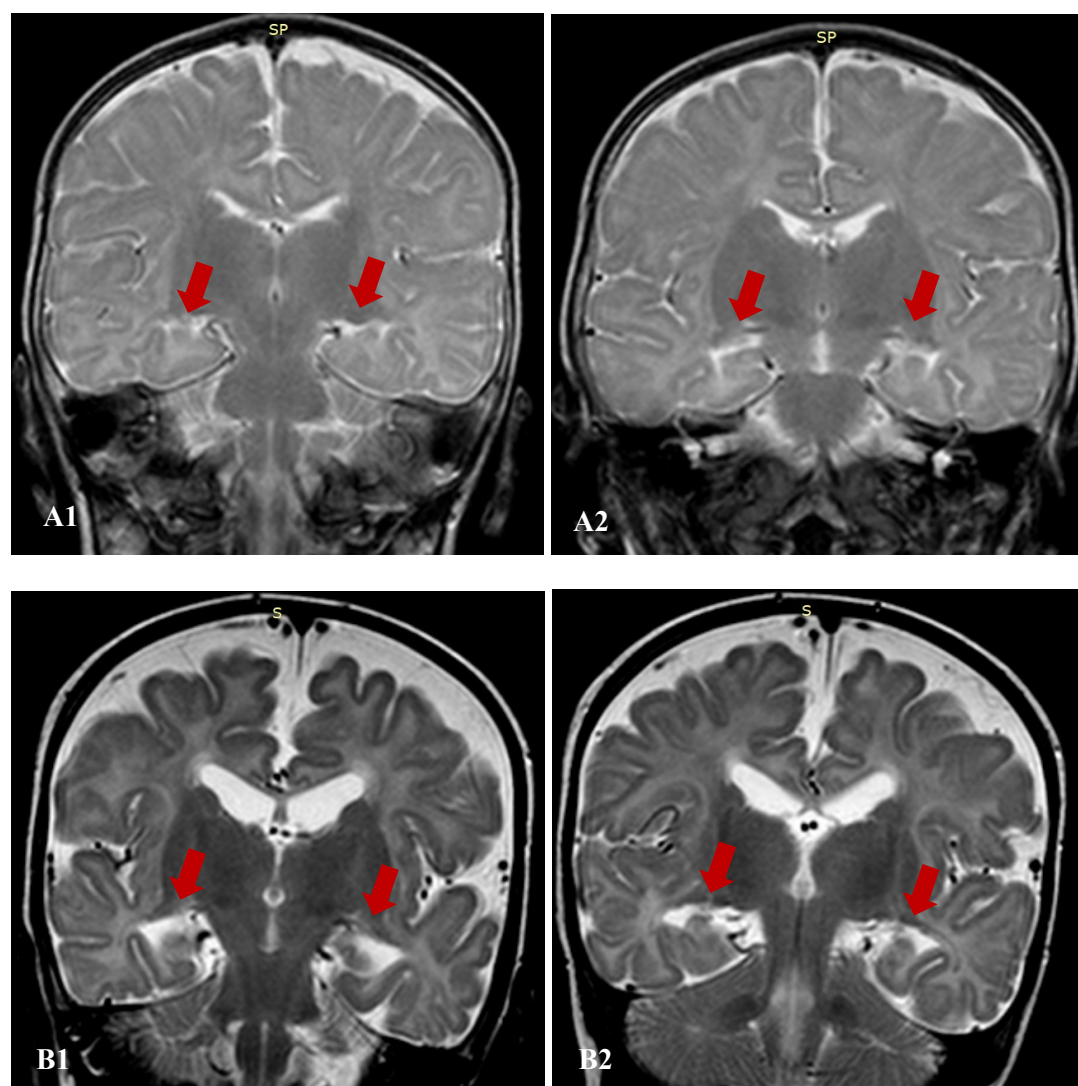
Examples of head MRI scans of patients, whose T2Scores were <2 , but because of the thick slices and poor resolution of images the measurement of hippocampal volumes was impossible. A1,2 – 1 month old boy 15 minutes long recurrent generalized seizures, developed epilepsy later on, B1,2 – 6 months old boy prolonged generalized tonic-clonic seizure, developed epilepsy later on.
